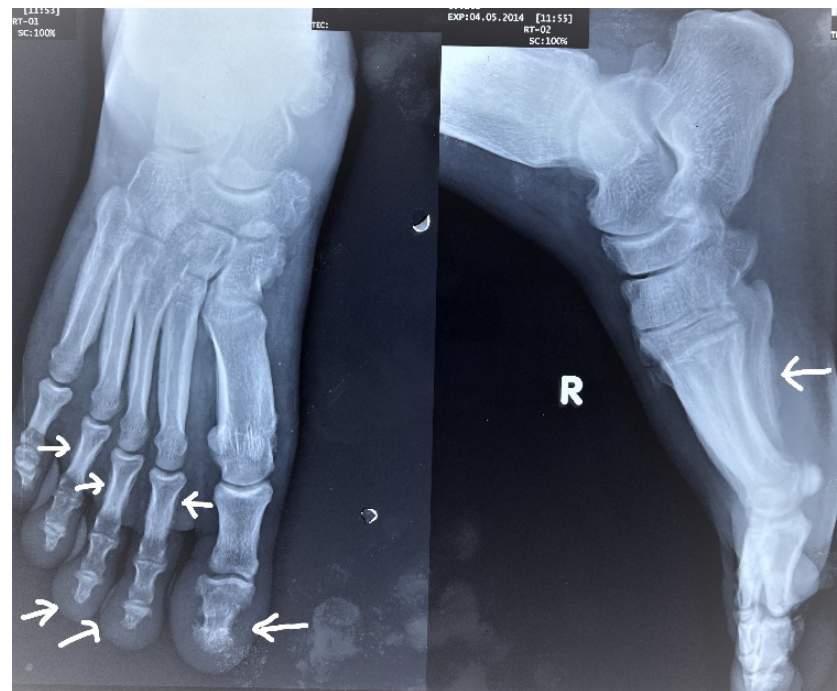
X-rays of right foot (2014) showing irregular periosteal hypertrophy with soft tissue swelling. The new bone formations affecting metatarsal bones and phalanges and the soft tissue swelling are marked with arrows.
